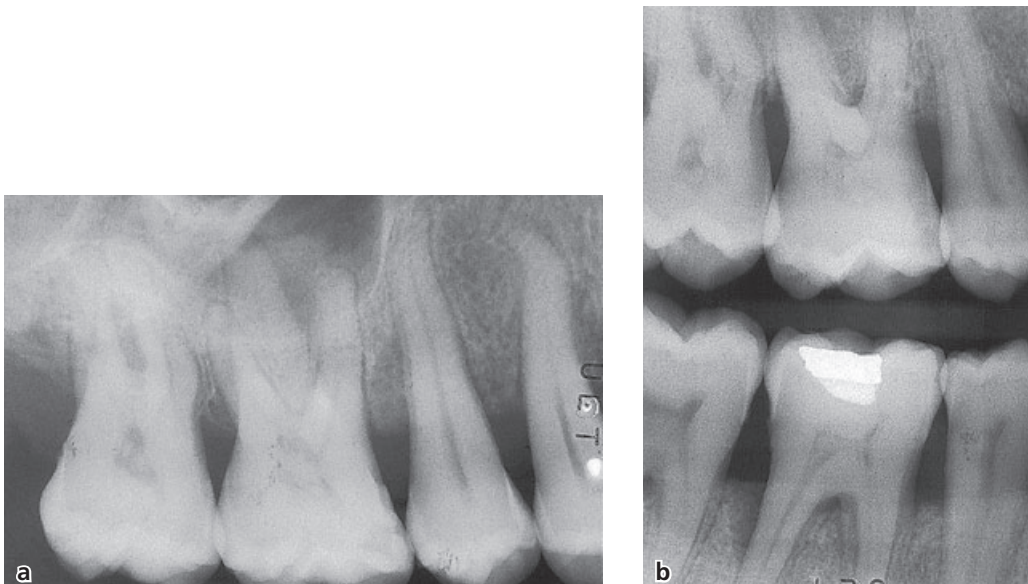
(a) Radiographs of the right maxillary molar region where, with a normal bisecting projection, the furcation defect of the first molar is not evident. (b) It is, however, easily identified in a bitewing radiograph.
